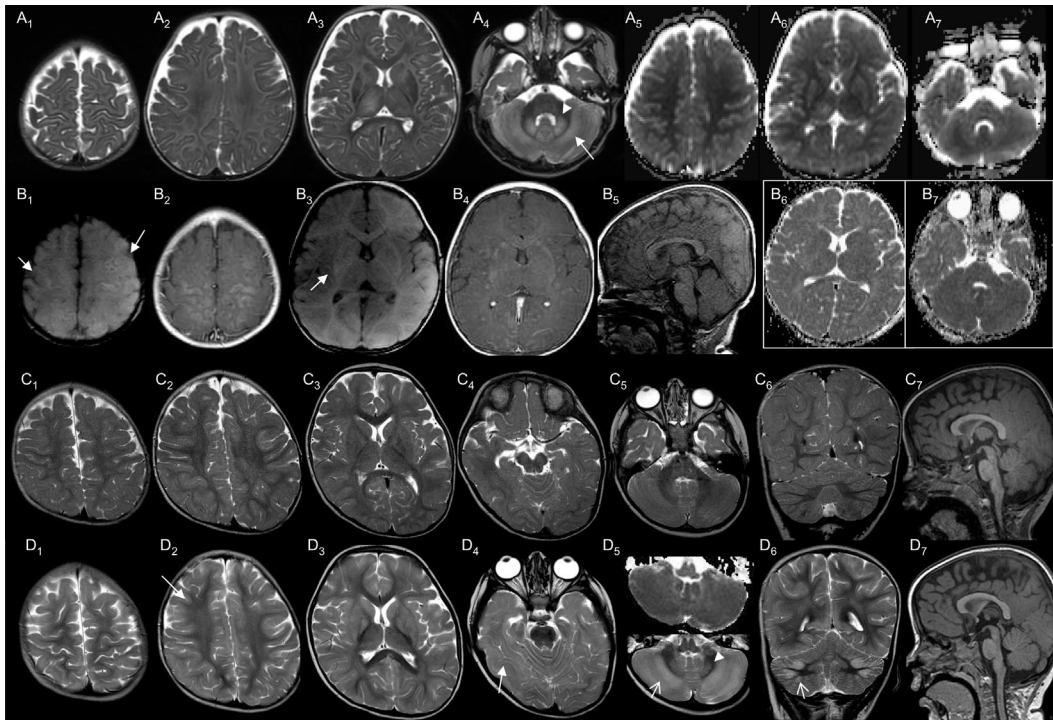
MRI in patients with acute, severe encephalopathy. A,B, 9-month-old AADCD_06 with profound hypoxic–ischemic injury: T2-hyperintense thalami, basal ganglia, and dentate nuclei (arrowhead;A_{3,4,6}). Focal T1-hyperintensity of cortex and right dorsal putamen (B_{1,3}) and more extensive gray matter enhancement (B_{2,4}). Extensive T2-hyperintensity of white matter (A₁₋₃) with restricted diffusion (A_{5,6}, compare with normal ADC-maps in B₆). Cerebellar watershed injury at depth of fissures (A₄, arrow) with restricted diffusion of cerebellar cortex and adjacent white matter (A₇, compare with B₇). C, Mild widening of supratentorial CSF spaces (C₁₋₅) in 17-month-old THD_10. D, New hypoxic–ischemic injury in THD_10 on follow-up at 25 months in deep gray matter and watershed areas: T2-hyperintensity of basal ganglia (D₃), temporo-occipital (arrow in D₄ compare with C₄), and cerebellar watershed areas (D₅, D₆, below; arrows) with pseudonormalized ADC (D₆, above). New, mild T2-hyperintensity of supratentorial white matter may be related to hypoxic–ischemic injury or represent white matter changes associated with neuronal disease (arrowhead D₂). Atrophy has progressed. (T2w: A₁₋₄, C₁₋₆, D₁₋₆; ADC: A_{6,7}, B_{6,7}; T1w: D₄; T1w: B_{1,3,5}, C₇, D₇; T1w + GAD: B_{2,4})
